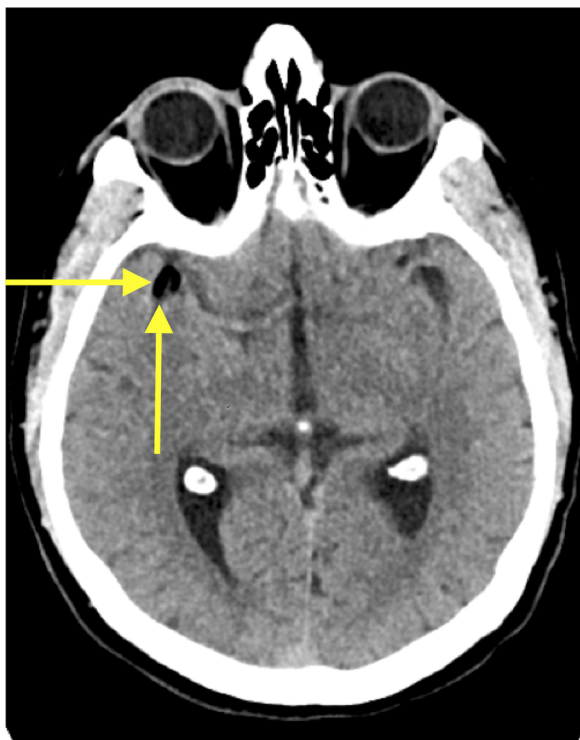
Non-contrast axial CT showing air density material near the expected bifurcation of the middle cerebral artery (arrows).
